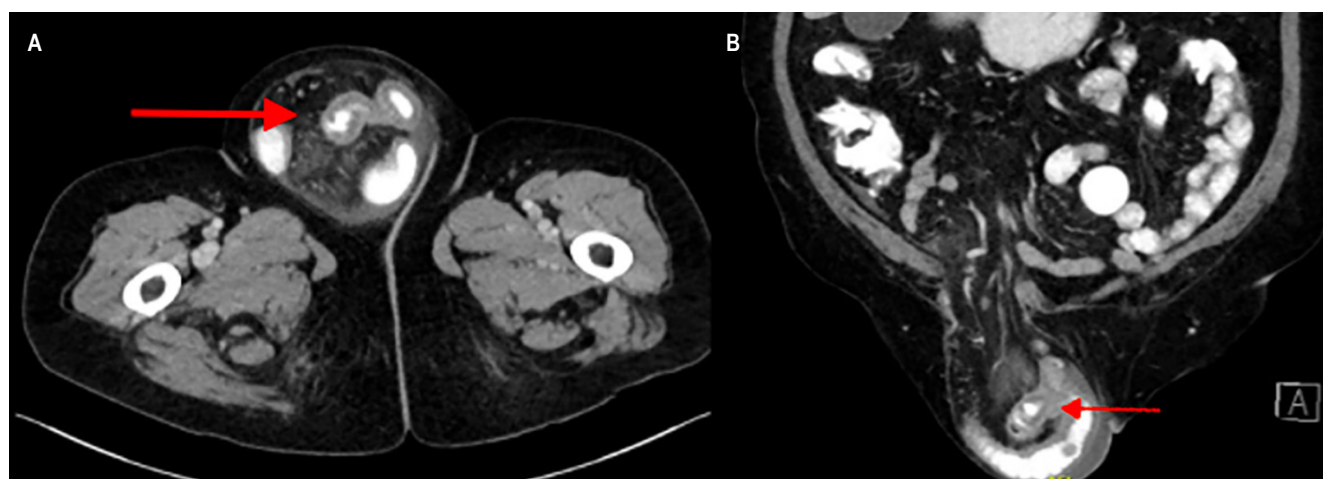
Axial computed tomography of the abdomen. A. Axial view. B. Coronal view. Hernial defect indicated by red line. Images property of the authors.
